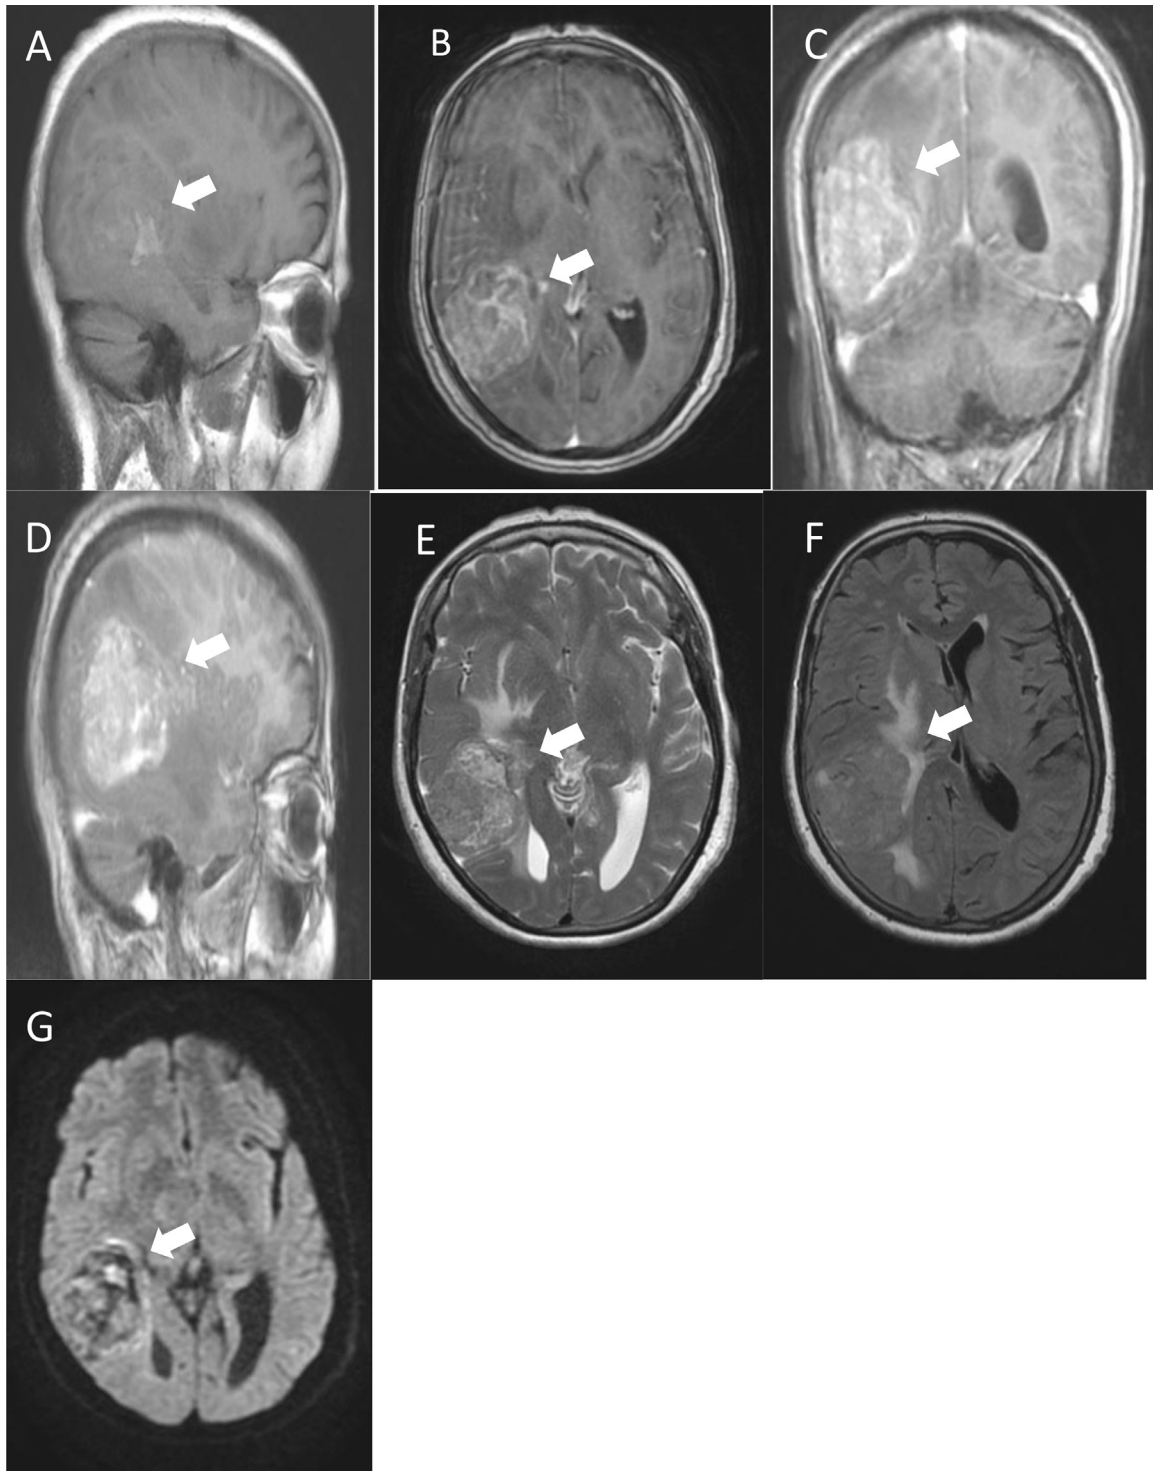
cerebral MRI images, T1sequence (sagittal section (A), injected axial section (B), injected coronal section (C) and injected sagittal section (D)), then T2 sequence axial section (E), FLAIR sequence axial section (F) and diffusion sequence axial section (G) objectifying a right parieto-temporo-occipital intra-axial process.
